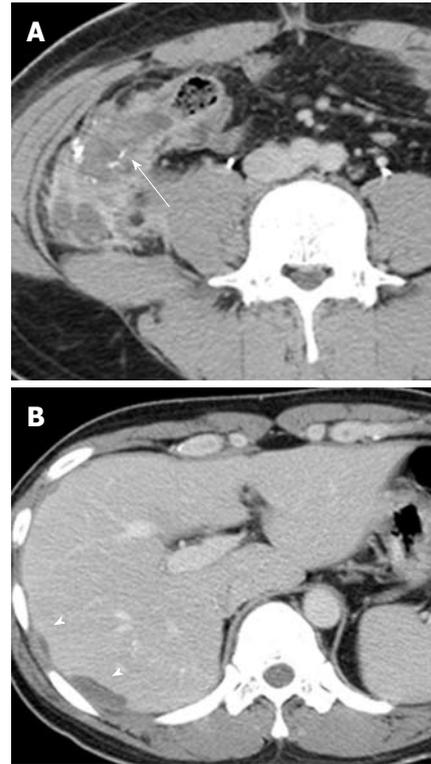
Mucinous cystadenocarcinoma of the appendix in a 26-year-old man. A: Contrast-enhanced CT image shows a complex hypoattenuating mass with enhancing solid portions and punctate calcifications in the appendix (arrow); B: Contrast-enhanced CT image of the upper abdomen shows loculations of fluid scalloping on the liver surface (arrowheads), providing evidence of a mass effect. CT: Computed tomography.
